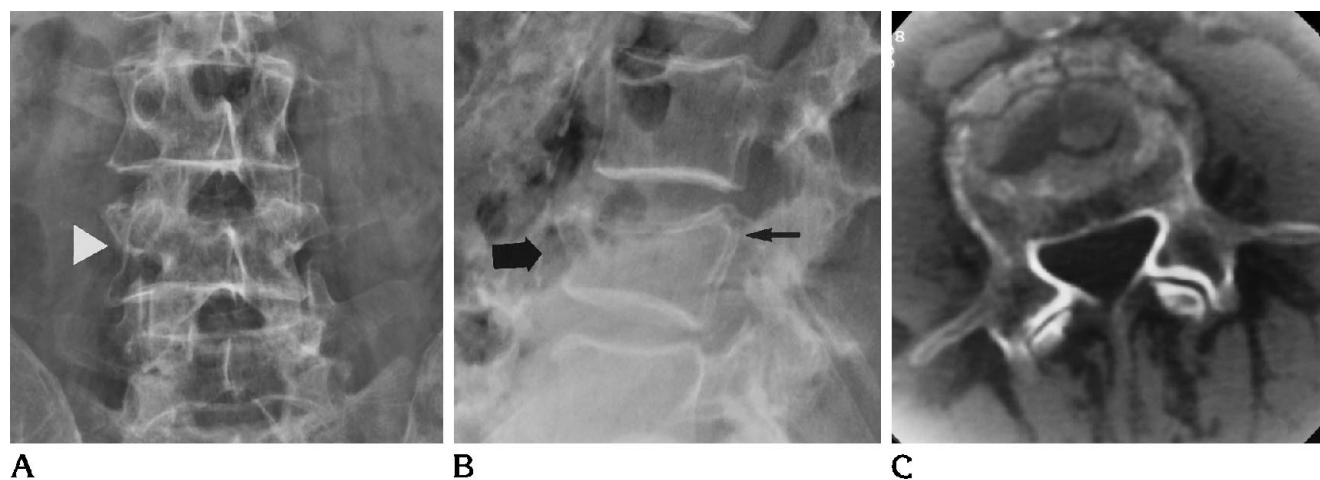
A and B, Plain films (anteroposterior and lateral) of an L-4 fracture (*thick black arrow and large white arrowhead*). Four of six plain-film readers called this "potentially unstable." The posterior vertebral line appears disrupted (*thin black arrow*), and the interpediculate distance appears widened.
